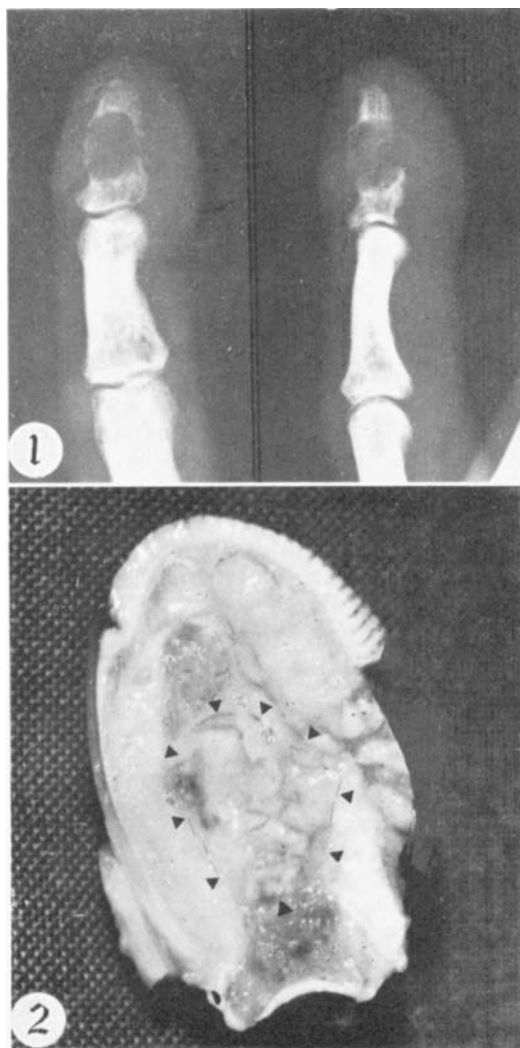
Roentgenograms (anteroposterior and oblique views) showing a lytic defect with a thin sclerotic border. A fracture line is seen traversing the cyst.
